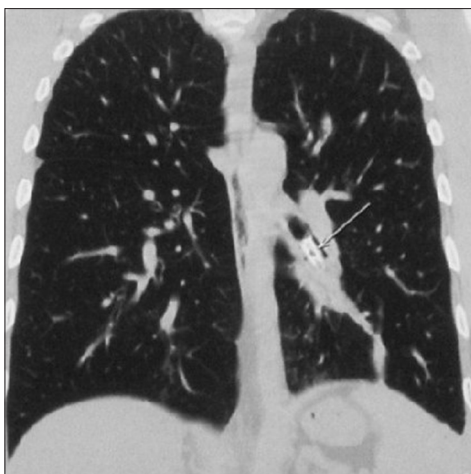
Contrast-enhanced computed tomography thorax showed presence of a foreign body in the left lower lobe bronchus
